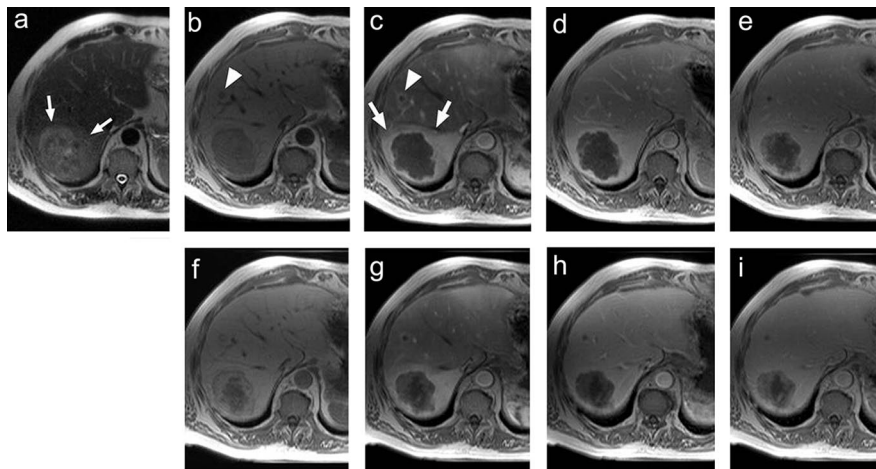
Metastases in a 64-year-old male patient with primary colorectal carcinoma. The unenhanced T2-weighted image (a) clearly reveals a large focal area (arrows) of hyperintensity of approximately 8 cm in liver segment VII. On the corresponding unenhanced T1-weighted image (b), this lesion is markedly hypointense against the surrounding normal parenchyma and a second, small hypointense area (arrowhead) is visible in liver segment VIII. During the arterial phase at 25 seconds after the first injection of gadobenate dimeglumine at 0.05 mmol/kg bodyweight (c), the large lesion is strongly hypointense and surrounded by a strongly hyperintense peripheral area (arrows). The second small lesion, not readily seen on the unenhanced T2-weighted image, can also be depicted together with a hyperintense rim (arrowhead), in liver segment VIII, indicating an infiltrative growth of the lesion. Both lesions are clearly seen as focal hypointense areas during the portal-venous (d) and equilibrium (e) phases after the first injection of gadobenate dimeglumine. On the delayed phase image (f) acquired at 60 minutes after injection both metastases have a characteristic target appearance. A similar pattern of behavior to that seen during the first dynamic series is seen during the second dynamic series (g, h, and i) acquired after a second injection of 0.05 mmol/kg gadobenate dimeglumine.
